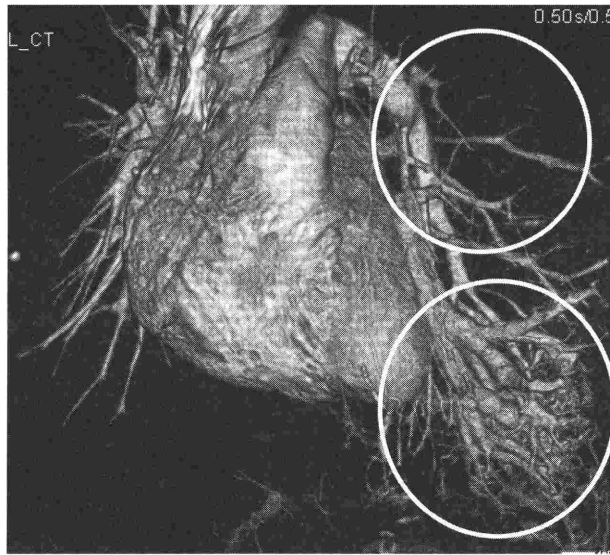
3D-CT examination of the chest
